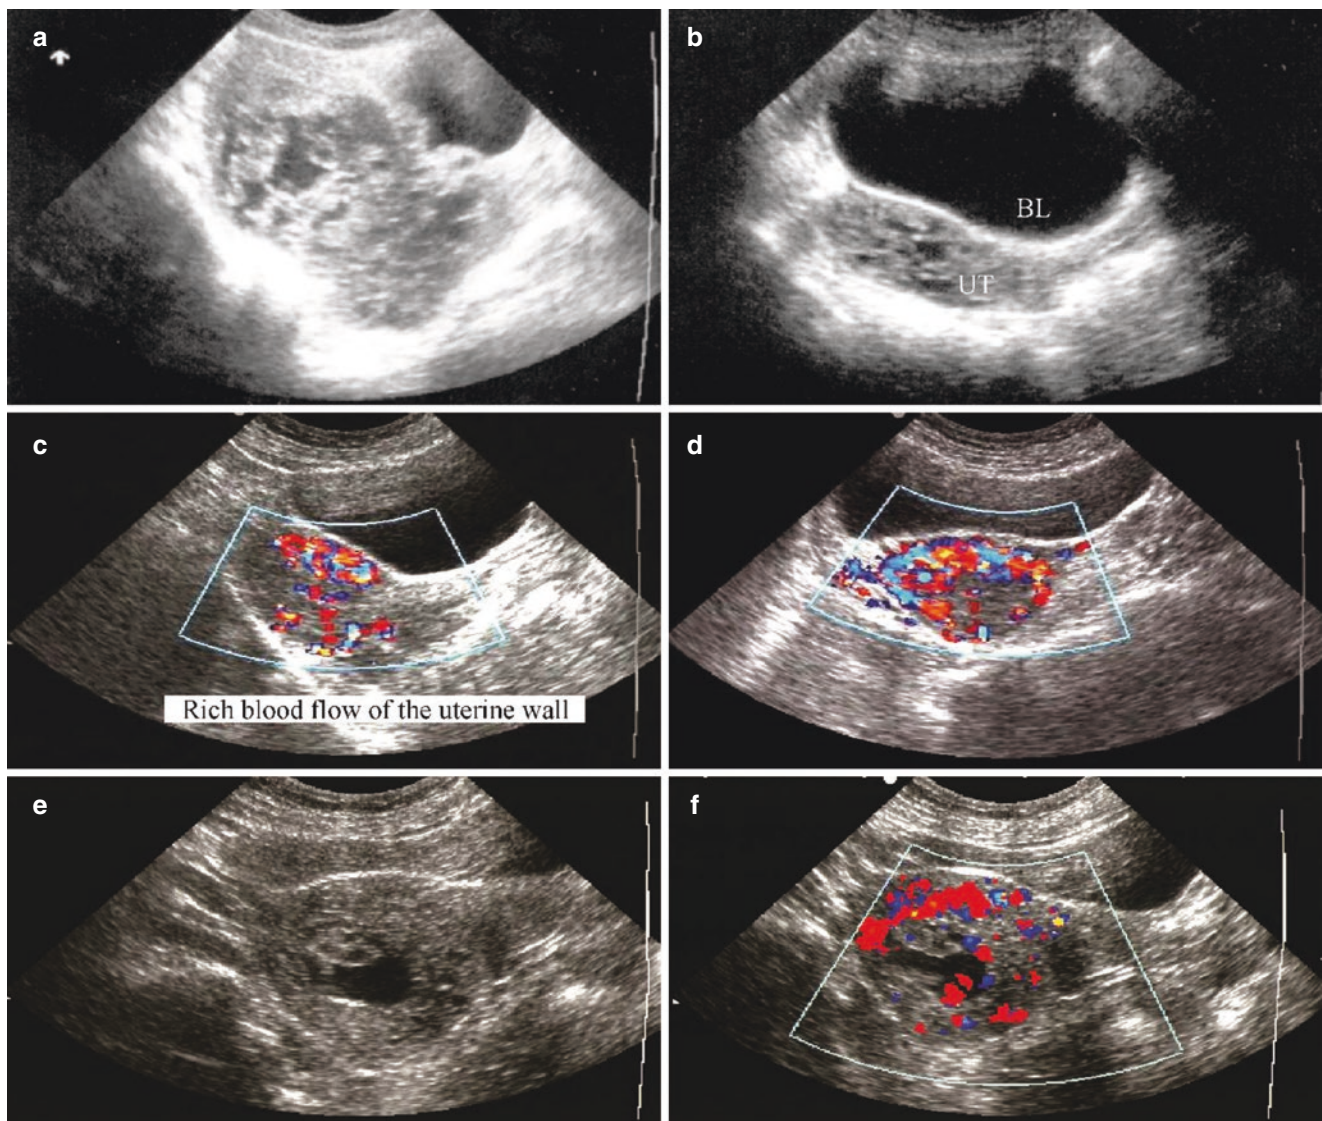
Invasive hydatidiform mole. (a). 4 months after the operation of hydatidiform mole, the uterus is enlarged with abnormal shape, the endometrium is disappeared, and hCG is high. Multiple “honeycomb” echo is shown in the uterine body and cervix. (b). The patient has irregular vaginal bleeding for half a year, with significantly increased hCG, and clinical diagnosis is choriocarcinoma. Ultrasound shows the absent endometrium and the inhomogeneous uterine body
